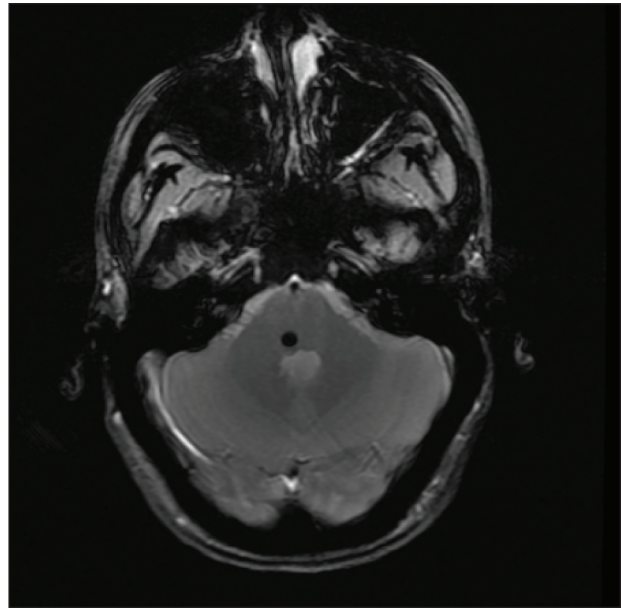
T2-weighted gradient-echo, magnetic resonance imaging (MRI) shows a right dorsal pontine cavernous malformation.
